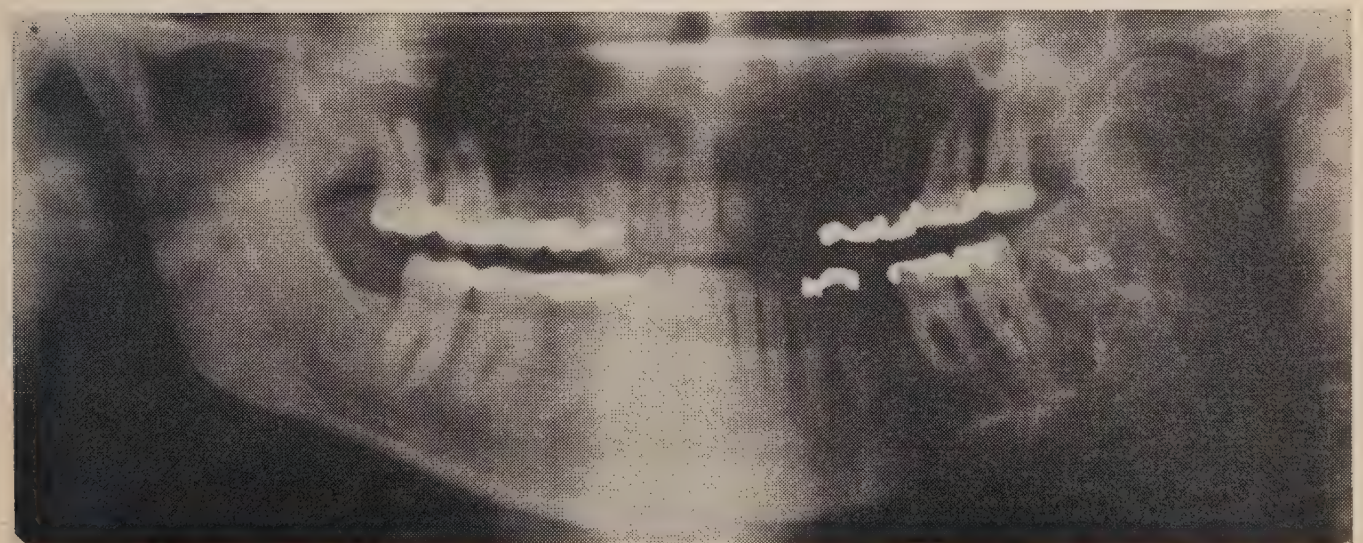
Panoramic radiograph produced by the Orthopantomograph. Evidence of fibrous dysplasia in left body and ramus of mandible. Also note radiolucent area in right coronoid process.
